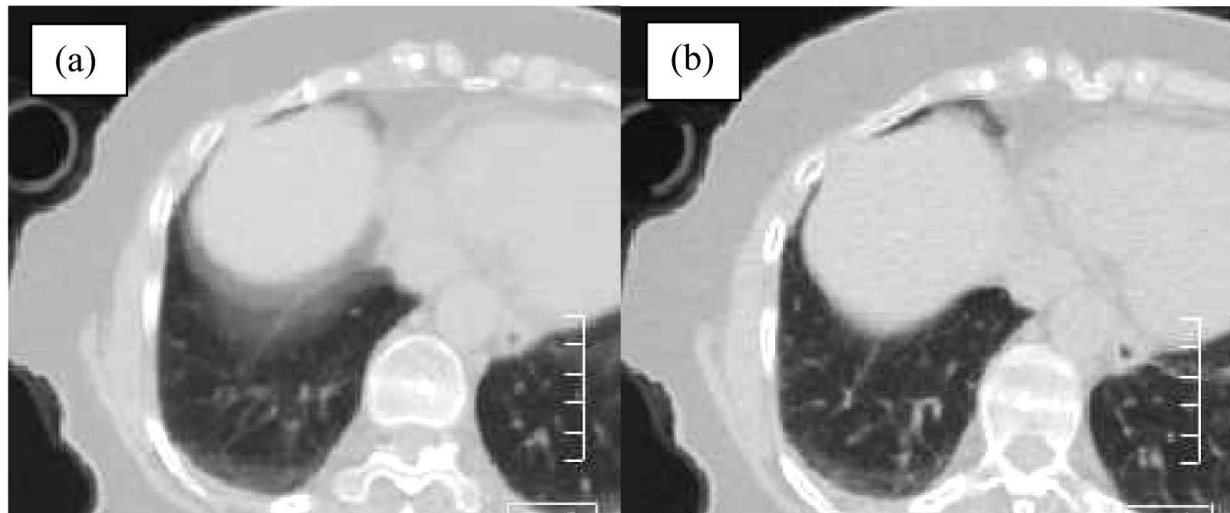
Comparison of (a) Non-Phased CT Image (i.e., From Conventional CT Imaging Technique) and (b) Phased Image (i.e., From 4-D CT Imaging Technique) of the Chest Region; Phased Image is Clearer Than Non-Phased One Because of the Elimination of Motion Effect
